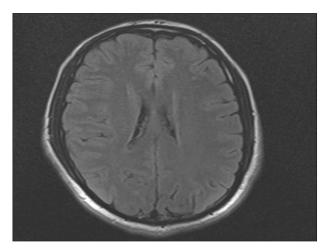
MRI brain FLAIR axial image showing tiny high signal area in left subcortical region.
